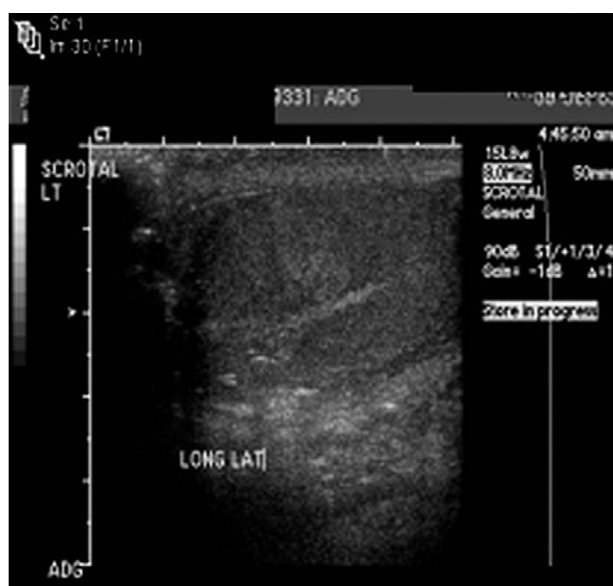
Ultrasound scan of scrotum revealing two 4-mm rubber pellets embedded within left testis.
